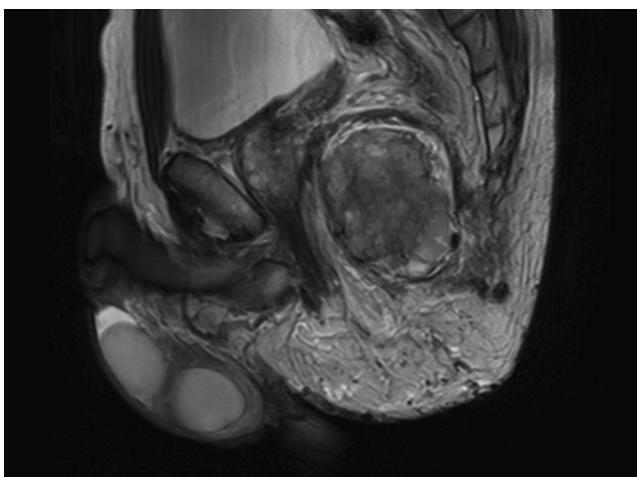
T2-MRI-Scan: the tumour in sagittal projection in the mesorectal tissue.
